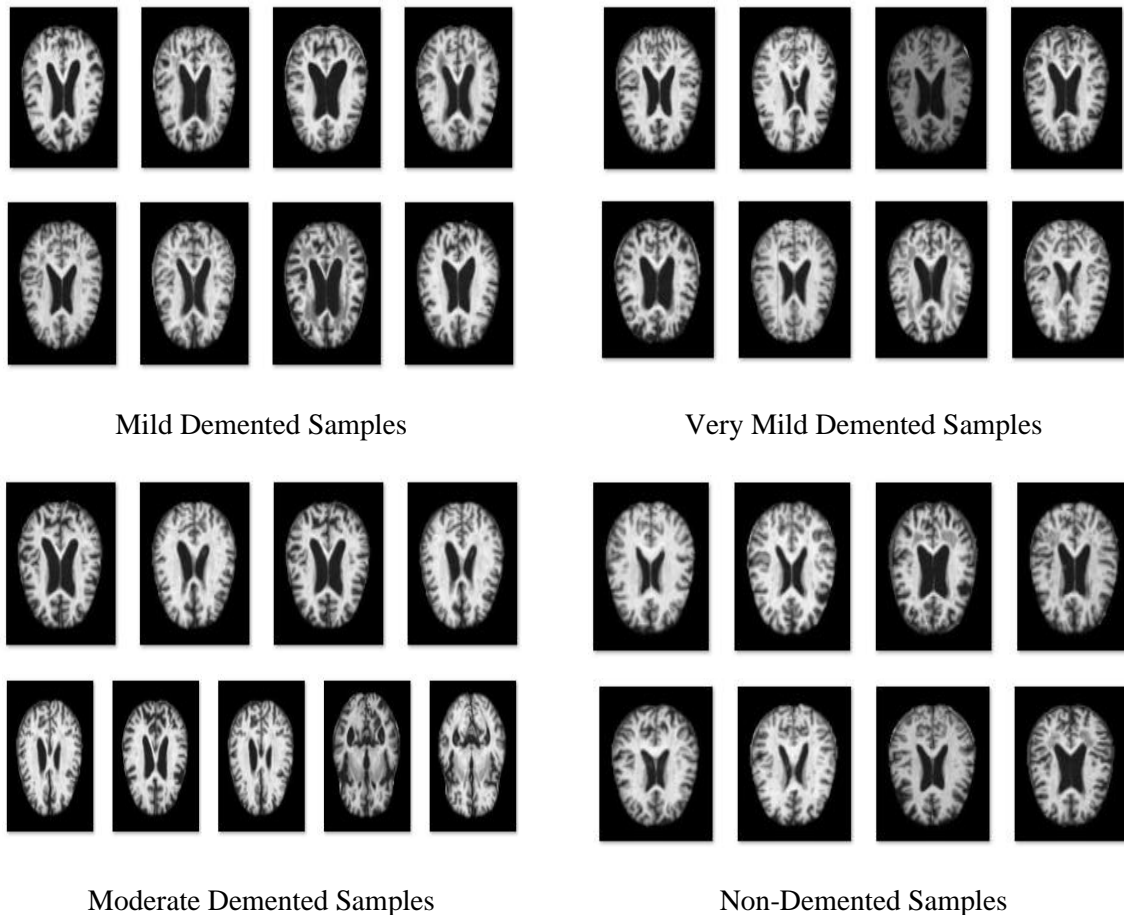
An Excerpt of Brain MRI Images from Dataset
